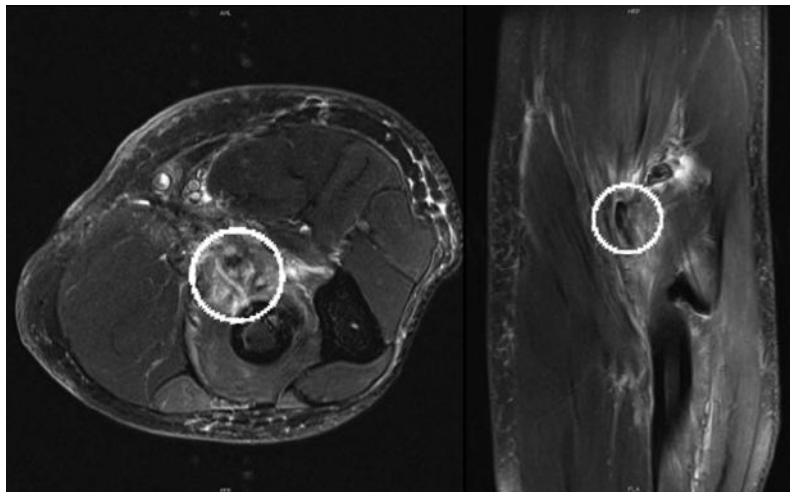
Axial (left) and coronal (right) fat-suppressed intermediate MR images depict increased signal in the extensor and supinator muscles compatible with muscle denervation. Post-surgical edema is noted anteriorly. The posterior interosseus nerve and its accompanying vessels are noted in the plane between the two heads of the supinator muscle (circled on left image). The avulsed biceps tendon is presented on the coronal image (circled on right image).
